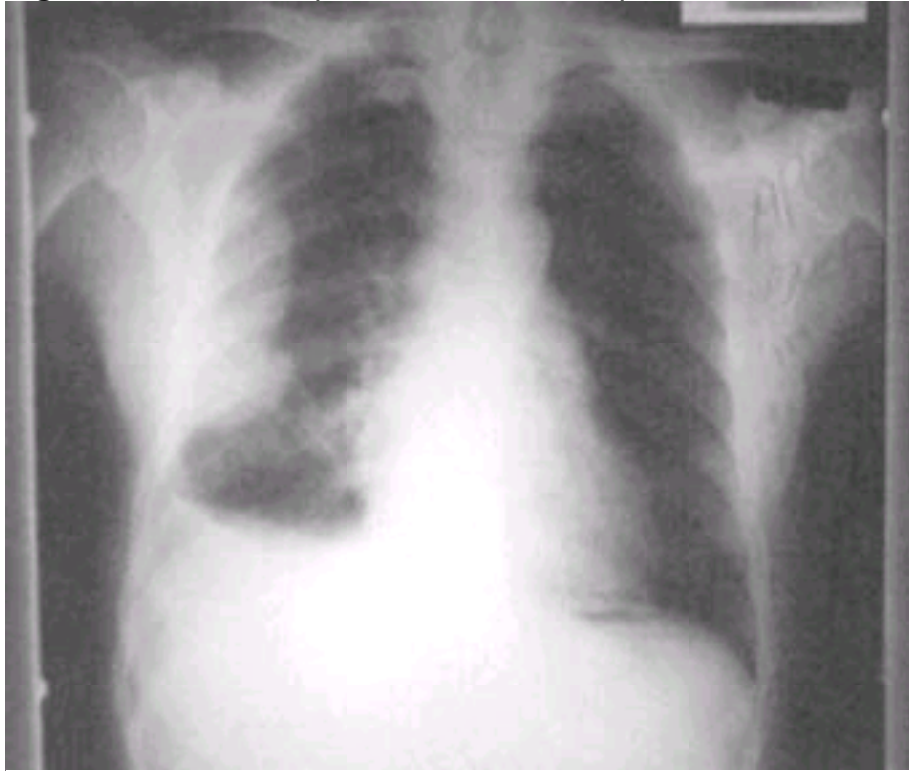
Right-sided pleural effusion. Posterior-anterior (PA) radiograph demonstrates blunting of right costophrenic angle. Both PA and lateral radiographs demonstrate the appearance of a meniscus.
